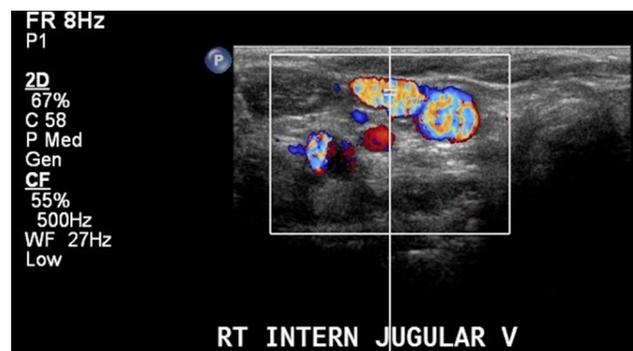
Doppler view of the internal and external jugular veins
